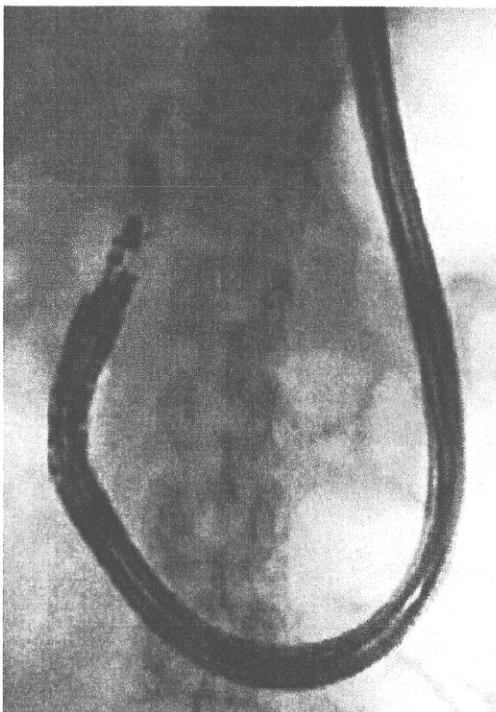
Cholangiogram obtained by endoscopic ultrasonography-guided puncture.
